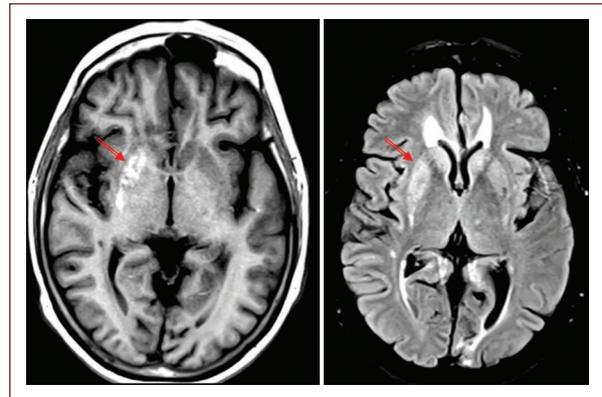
Axial T1-weighted and fluid-attenuated inversion recovery magnetic resonance imaging of case 1 demonstrating a hyperintense lesion in the right striatum (arrow), consistent with diabetic striatopathy.
